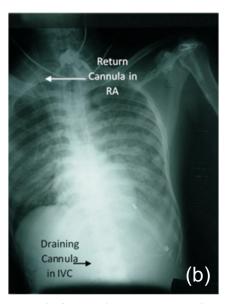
Chest radiographs at presentation (a) and after 10 days on ECMO (b)
